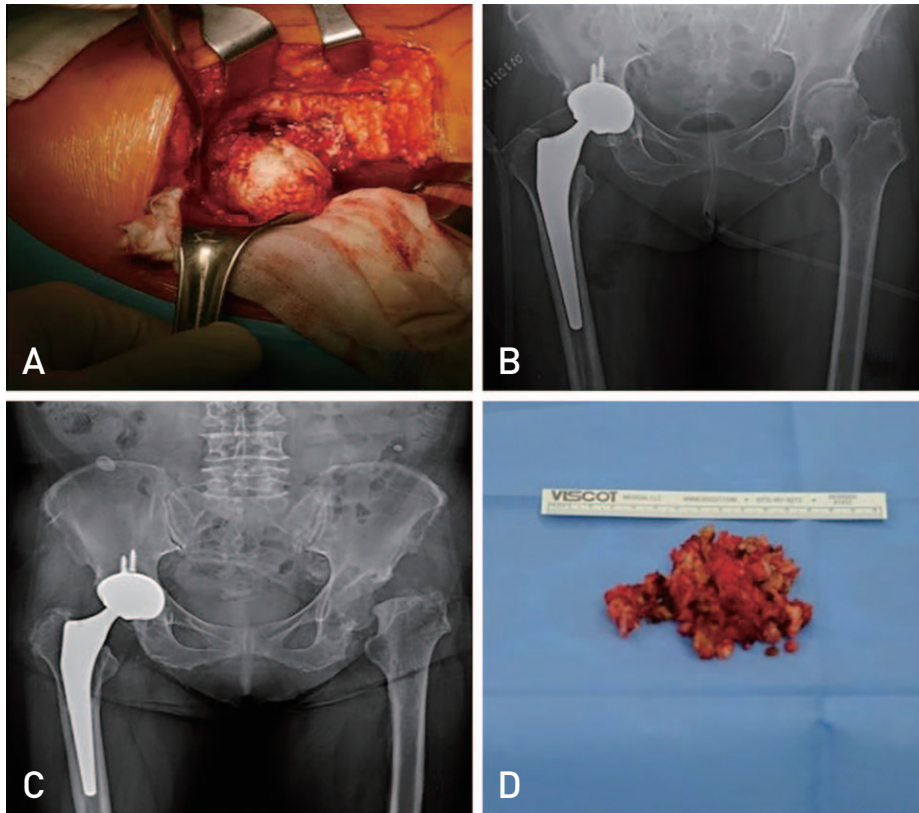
(A) Intraoperative image shows that femoral head was collapsed. (B) Anteroposterior view of X-ray image shows that right hip joint was changed with implant and right hip joint is intact. The implant was used by Bencox ID stem and cup (Corentec, Seoul, Korea). (C) The follow-up image after 8 months shows that right femoral head was replaced by implant and left femoral head was collapsed. (D) Removed soft tissue and femoral head show that inflammatory change.
